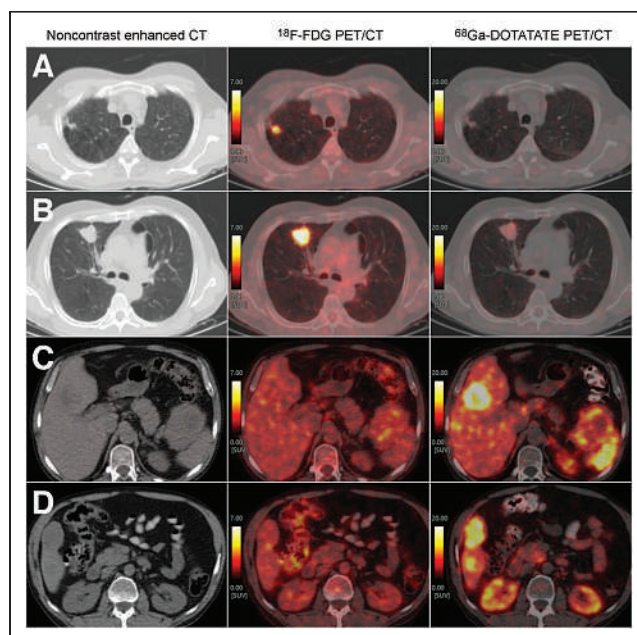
Follow-up dual-tracer transaxial PET/CT images showing ^{18}F -FDG-avid (SUV_{max} , 10.9), non-SSTR-expressing (SUV_{max} , 4.7) lung lesions in right upper lobe (A and B); non- ^{18}F -FDG-concentrating (SUV_{max} , 2.8), highly SSTR-expressing (SUV_{max} , 29.4) hypodense segment V lesion in liver and nodal mass at splenic hilum (C); and similar non- ^{18}F -FDG-concentrating (SUV_{max} , 2.4), highly SSTR-expressing hypodense segment VI lesion in liver (SUV_{max} , 26.5) (D).
